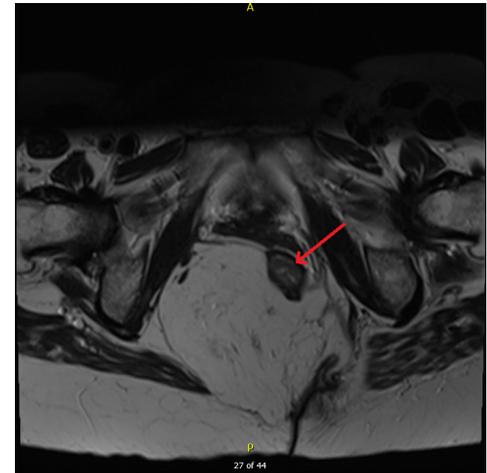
MRI axial view of the mass showing displacement of the lower rectum posteriorly to the left (red arrow). The mass was situated above the levator muscles and not involving the sphincter complex.
